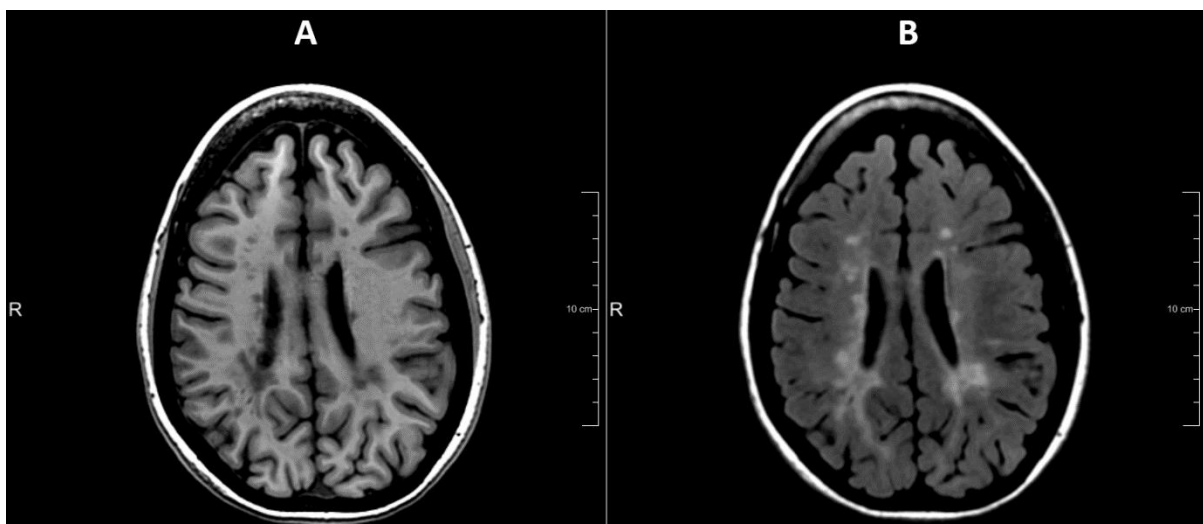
MRI showing lesions in a brain afflicted with MS. A) T₁ weighted scan showing dark “holes” in the white matter indicative axonal loss. B) A FLAIR image of the same patient showing larger volumes and numbers of lesions than the T₁ scan. Image taken from <http://www.diagnijmegen.nl/images/d/db/Mriwebsite.png>
